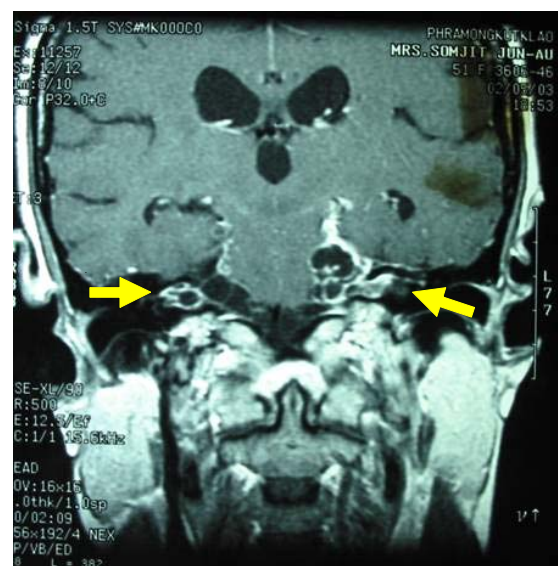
Axial MRI brain T1 weighted : multiple cystic lesions at prepontine cistern and bilateral cerebellopontine angle (arrows)
